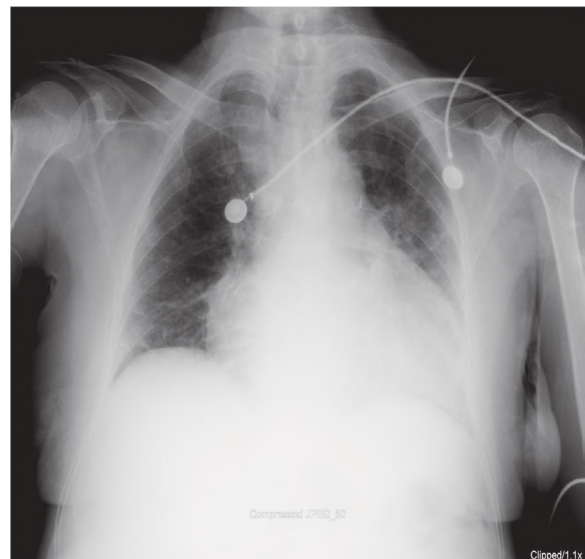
Chest radiograph of the patient showing cardiomegaly.
